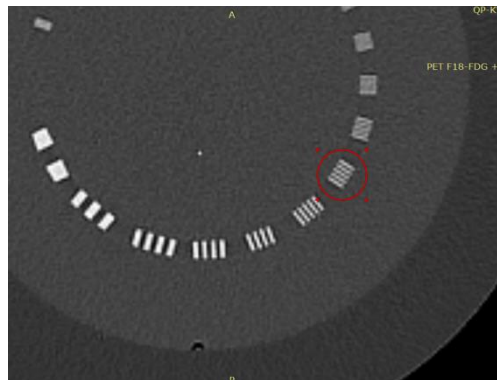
example of resolution in CT image
